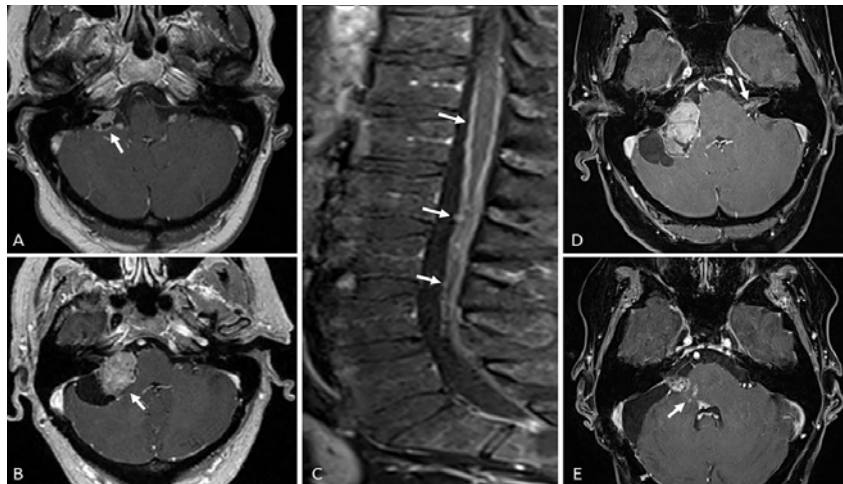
A) Axial T1-weighted contrast enhanced MRI of the head showing a right CP angle tumor with both solid and cystic components; B) Axial T1-weighted contrast enhanced MRI of the head 2 years later shows a significant increase in size; C) Sagittal T1-weighted fat saturated contrast enhanced MRI of the lumbar spine showing multilevel leptomeningeal deposits; D) Axial T1-weighted contrast enhanced fat saturated MRI of the head showing leptomeningeal spread along cranial nerves VII & VIII; E) Axial T1-weighted contrast enhanced fat saturated MRI of the head showing new patchy enhancement along the right middle cerebellar peduncle and right dorsal pons extending to the right facial colliculus consistent with radiation necrosis versus intraparenchymal tumor spread.
